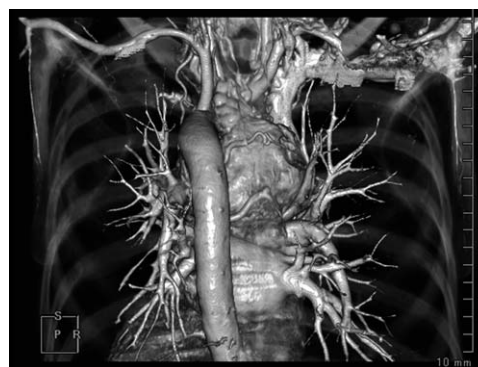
Three-dimensional computed tomography showing 2 thick feeding vessels (right bronchial arteries) on the back side of the tumor.
